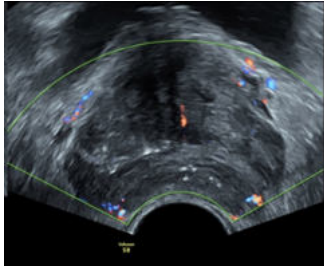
Same case as above on Colour Doppler study showing increased central vascularity
